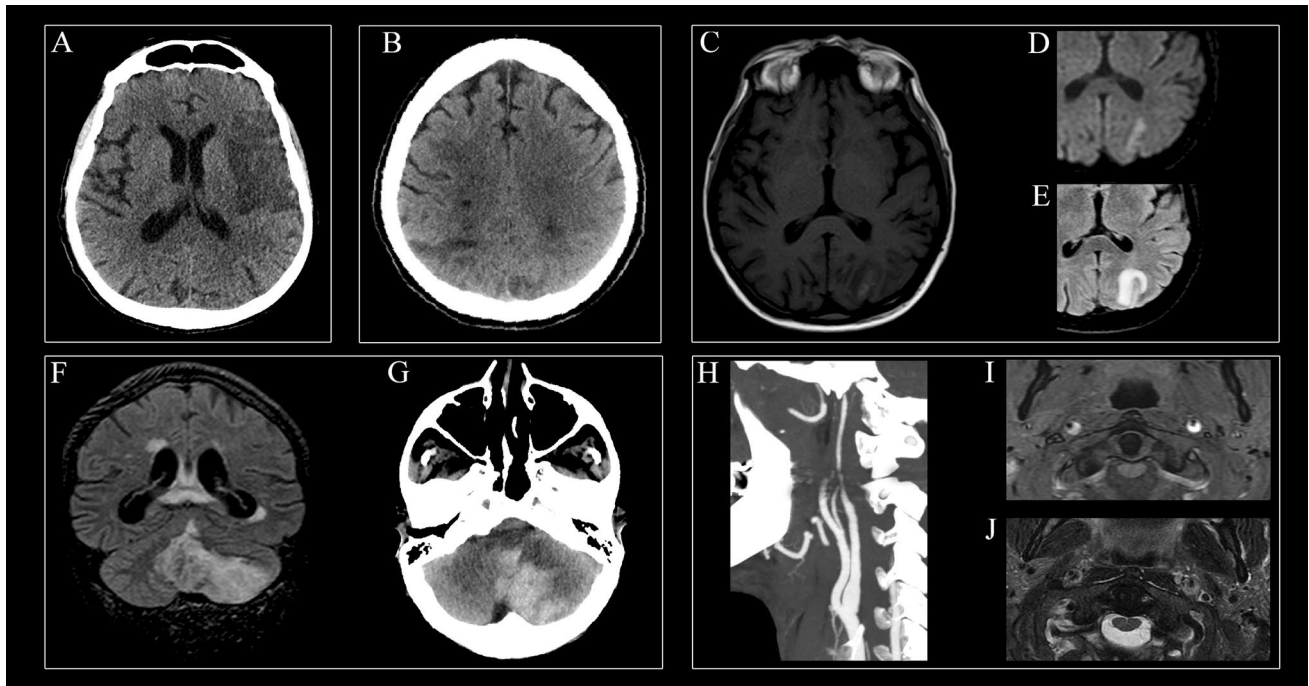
Neuroimaging features of COVID-19-associated stroke. a A 70-year-old man with critical COVID-19-related ARDS developed acute right-sided weakness. Brain CT showed a large fronto-insular ischemic lesion within the vascular territory of the left middle cerebral artery. b A 64-year-old man with COVID-19 infection developed multi-organ failure. Brain CT showed multiple recent ischemic lesions involving cortical-subcortical regions of both parietal lobes and centrum semiovale. c–e A 67-year-old man with COVID-19 and critical ARDS presented myocardial infarction 2 days after hospitalization. On day 14, he developed a tetraparesis. Brain and spine MRI were requested. As an incidental finding (given the final diagnosis of critical illness neuropathy), brain MRI showed a left parieto-occipital infarction, hyperintense on T1-weighted images (c) and bright on DWI (d) along the cortex, with subcortical white matter perilesional edema on FLAIR sequence (e). f–g A 72-year-old man diagnosed with COVID-19 presented with ataxia and vomiting. MRI showed
